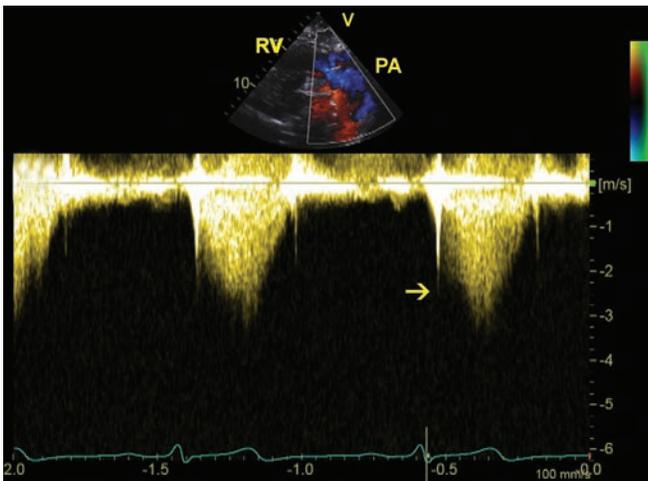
Continuous wave Doppler through the pulmonary valve measures 2.5 m/sec (arrow).
